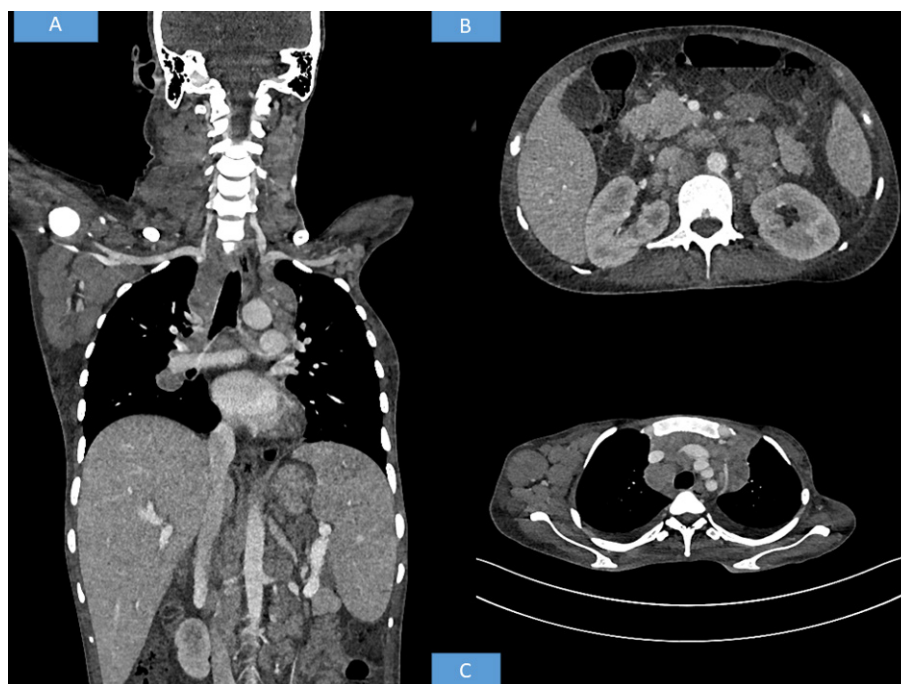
Radiological findings. (A) Whole body CT shows hepatosplenomegaly with axillary and cervical lymphadenopathy. (B) CT shows retroperitoneal enlarged lymph nodes. (C) CT shows axillary and mediastinal lymphadenopathy.
